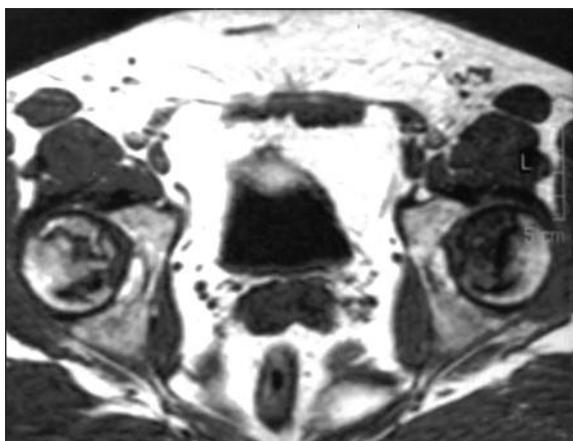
MRI scan image revealing evidence consistent of bilateral avascular necrosis of femoral head.
